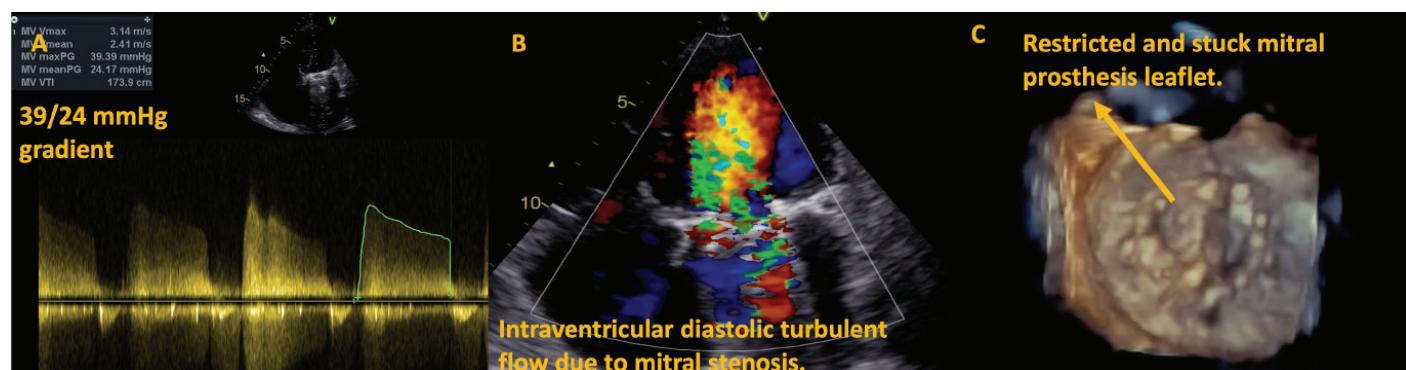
A-C: In 2D and 3D transesophageal echocardiography images of increased mitral prosthetic heart valves gradient, Intraventricular diastolic turbulent flow due to mitral stenosis, and restricted leaflet movements
